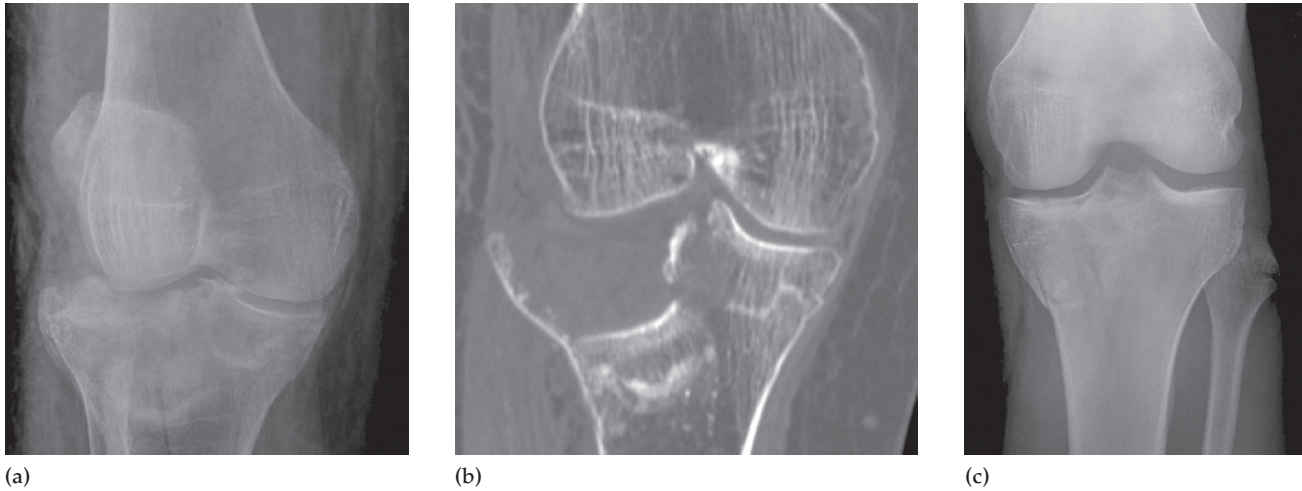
Tibial plateau fractures. A lateral tibial plateau fracture can occur when a car strikes the outer side of the knee ('bumper fracture'). (a) The tibial plateau is fragmented and is driven down into the tibia. (b) CT showing the depression, which requires surgical treatment. (c) A similar injury can occur to the medial tibial plateau.
